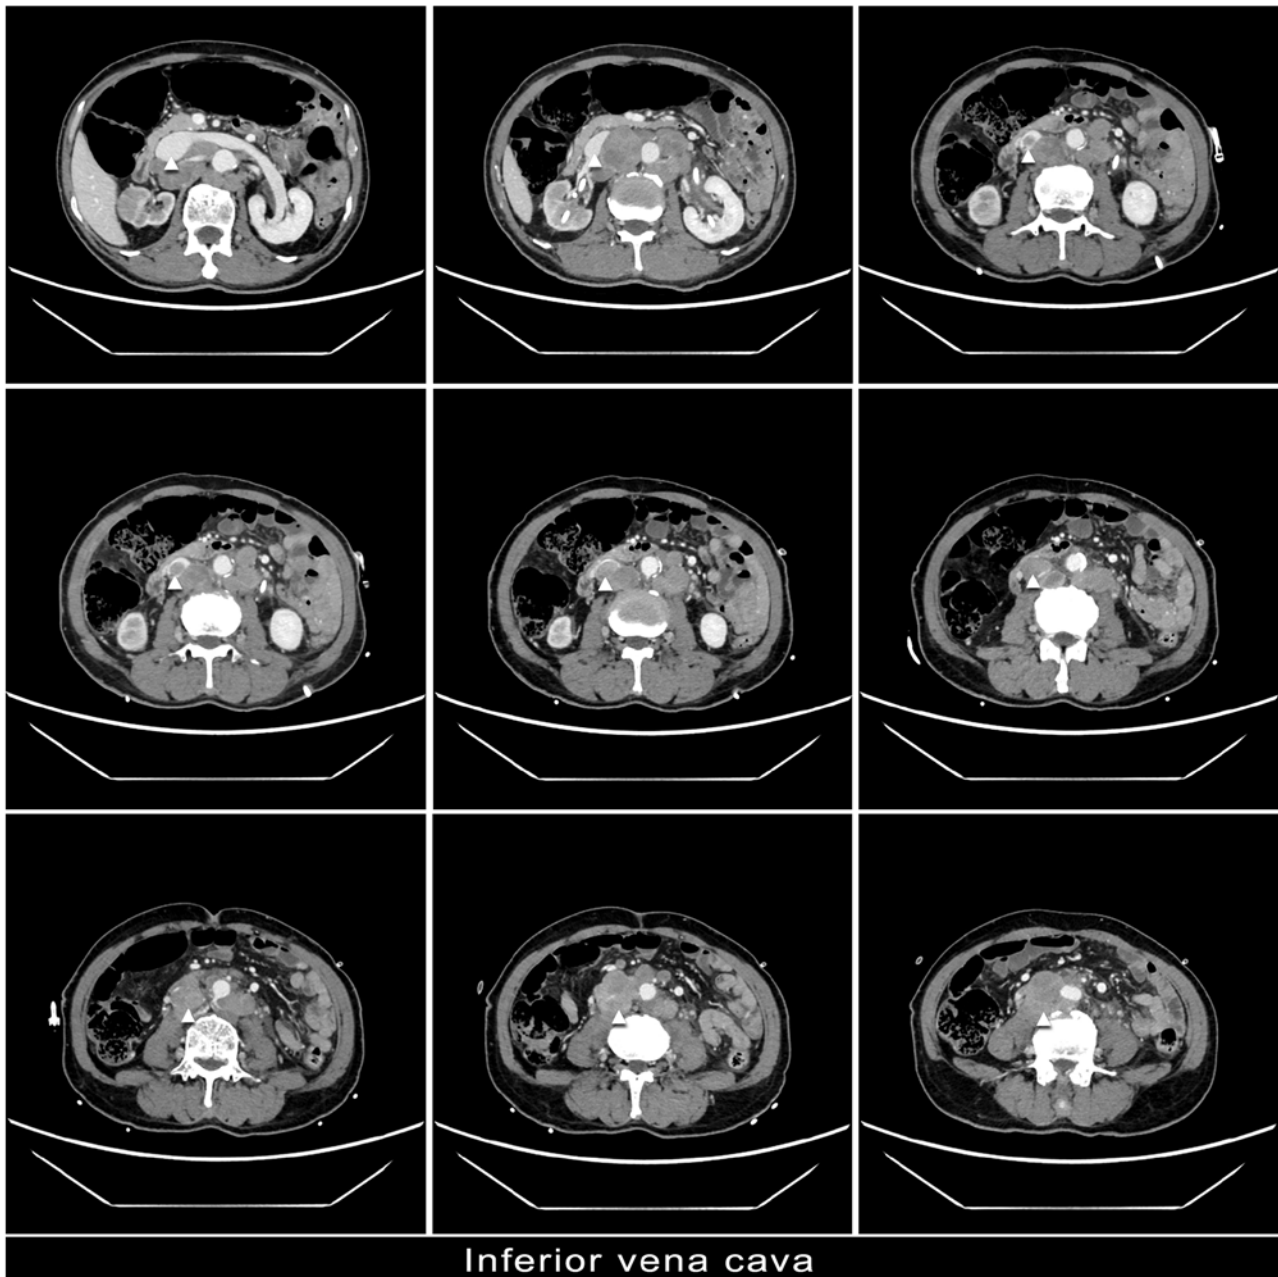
Enhanced computed tomography venous phase images. No enhancement was observed in the segment of the inferior vena cava, spanning from the plane of the right renal vein to the bilateral external iliac veins. Triangles indicate the inferior vena cava.
